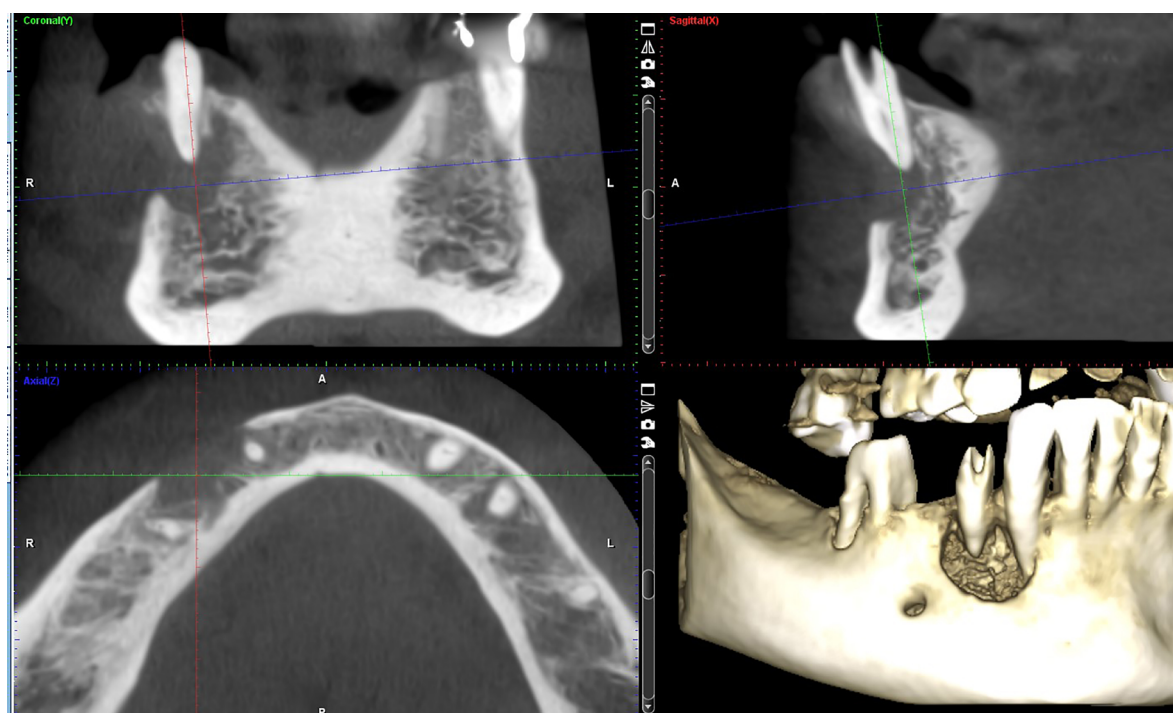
CBCT image of the lesion.
